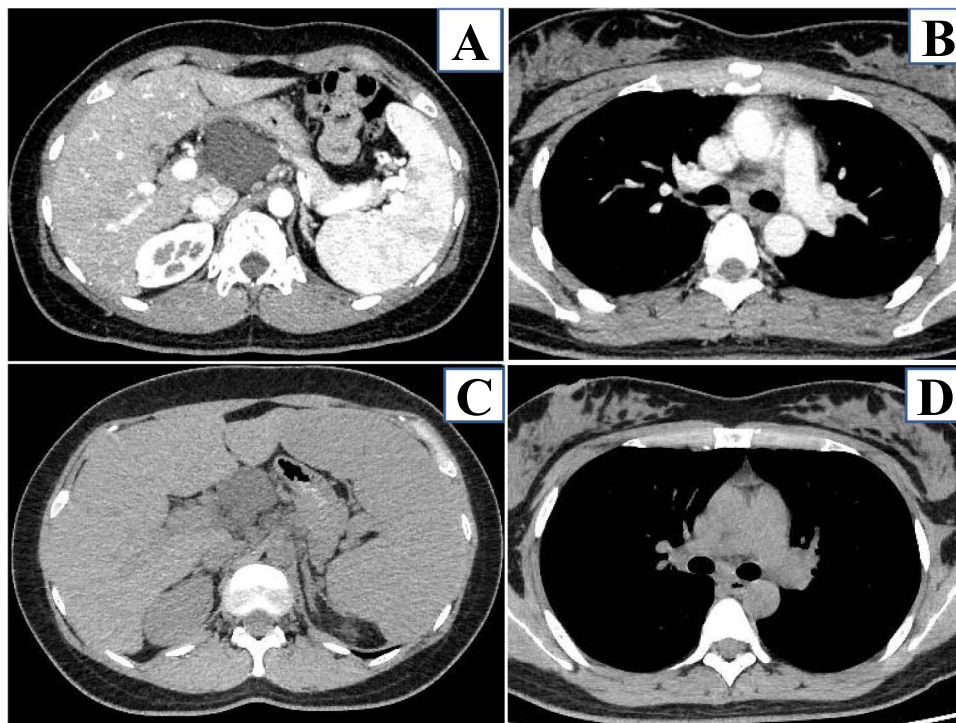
Computed tomography at the initial visit to our hospital shows a cystic mass in the pancreatic head and mild splenomegaly (A) without enlarged lymph nodes in the mediastinum or pulmonary hilum (B). Ten months later, an obvious increase in splenomegaly (C) but no significant lymph node enlargement in the thorax is seen (D).
